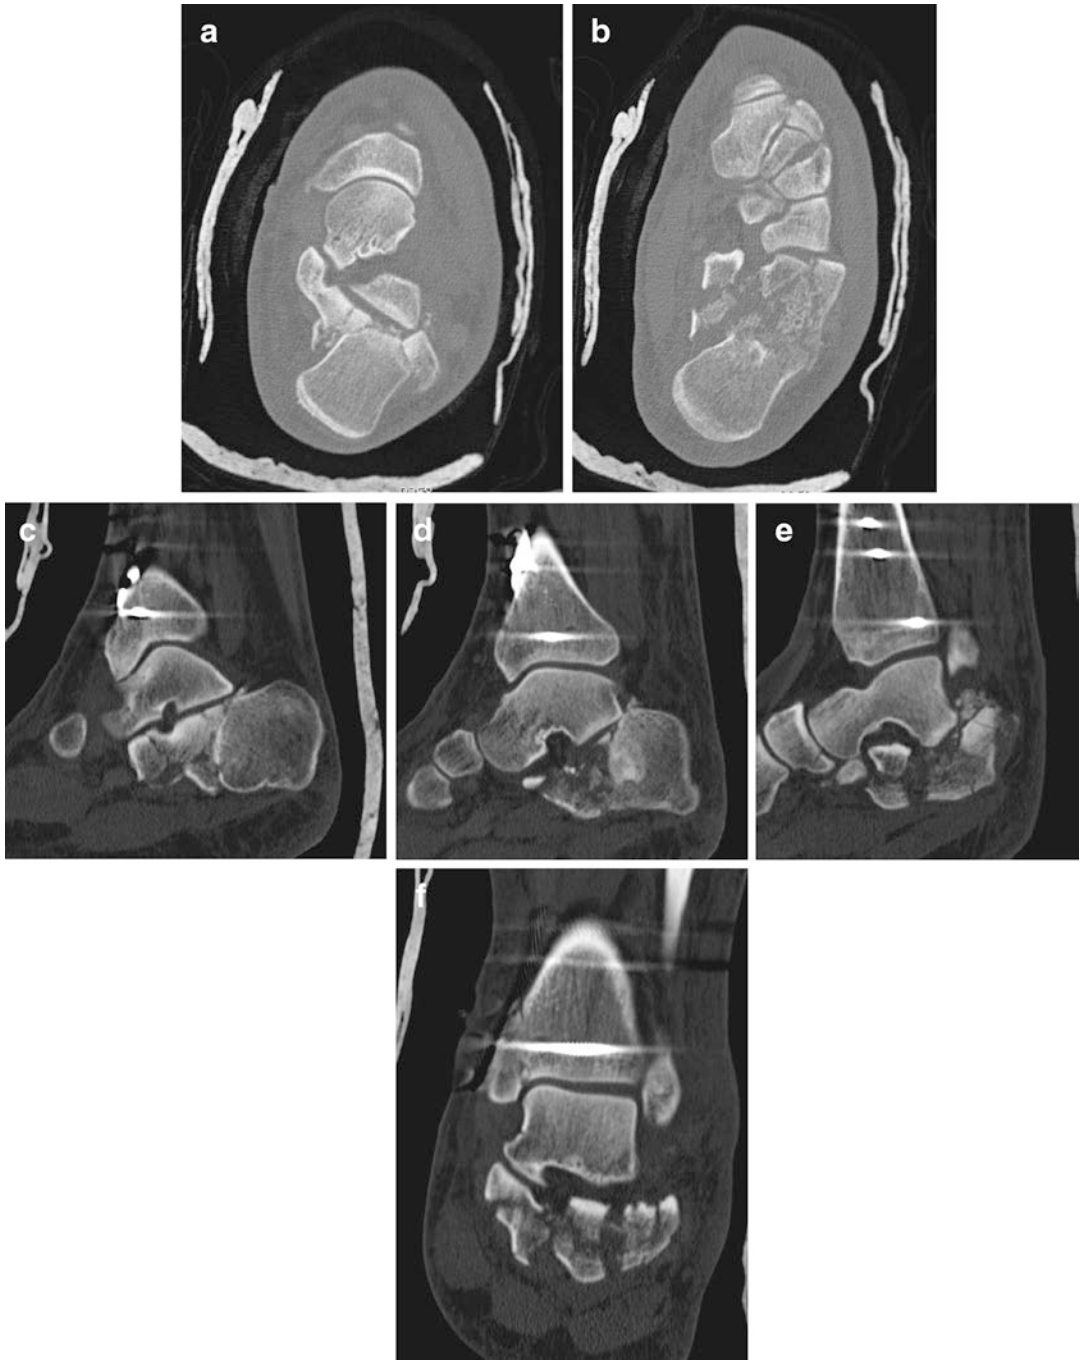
(a, b) Axial CT of the calcaneus (c–e) Sagittal CT of the calcaneus (f) Coronal CT of the calcaneus
